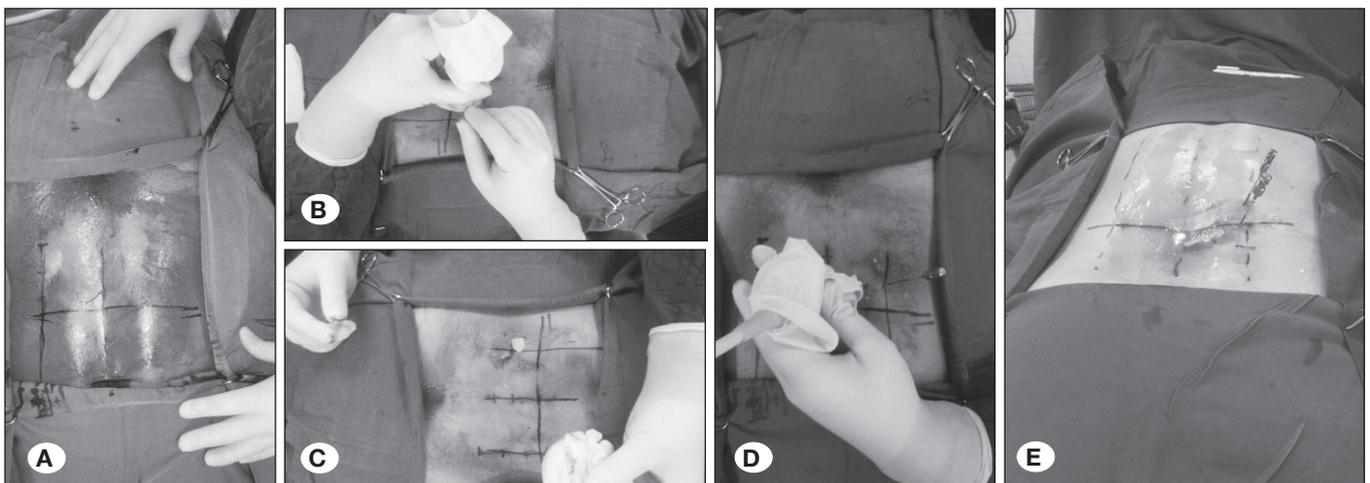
The steps of preparations and injection: praping, draping and marking (A), insertion peripheral catheter in parasagittal approach (B), the inserted catheter (C), inserting epidural catheter parallel to peripheral catheter, bringing the peripheral catheter out and continuing the path of epidural needle sonographic guided (D) and the final position of epidural needle (E).
